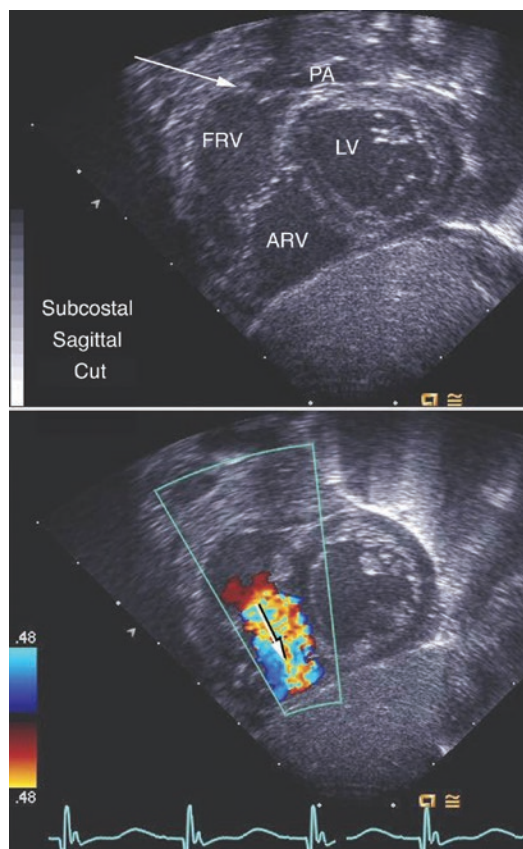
This subcostal sagittal cut shows a series of images in gray scale above with Doppler color flow superimposition below in a milder form of this anomaly. In this example the functional right ventricle (FRV) is larger and the pulmonary artery (PA) more prominent. The atrialized right ventricle (ARV) lies on the diaphragmatic or acute marginal surface of the heart. The tricuspid jet in the bottom frame is directed toward the diaphragm. LV left ventricle
